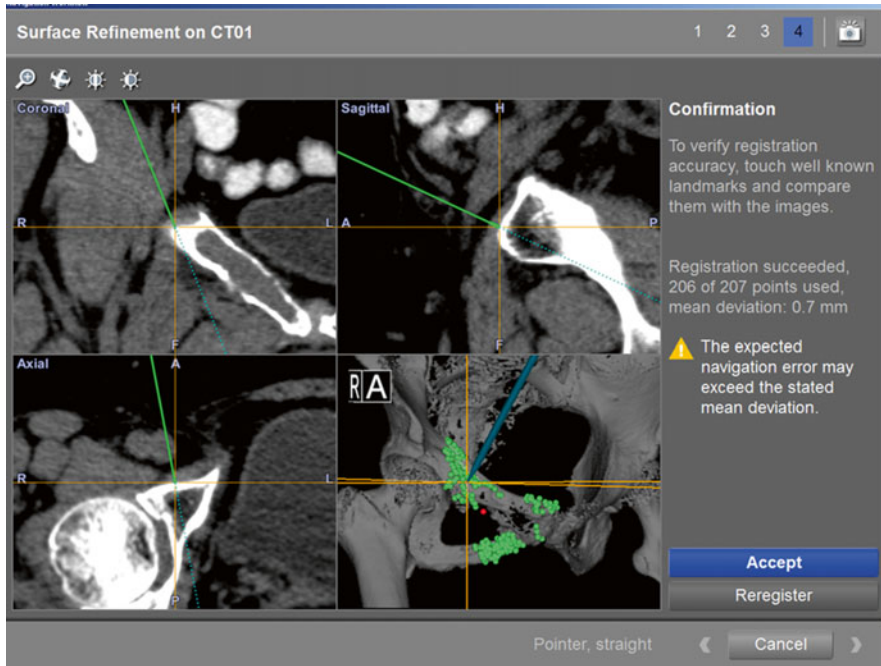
Shows the navigation display after paired-points and surface registration during a CT-based navigated resection in a patient with right pubic malignant tumor. The registration error generated from the navigation machine was 0.7 mm. By placing the navigation probe on the bone surface, the tip of the navigation probe was exactly matching to the preoperative images, thereby verifying the registration accuracy before we can rely on the preoperative images to execute the surgical planning
